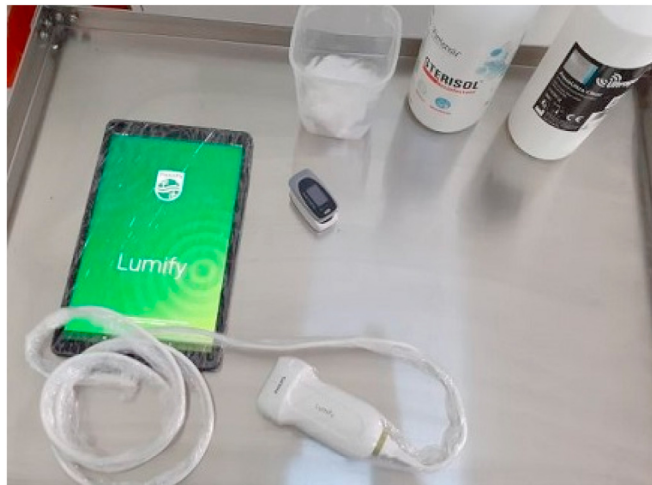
The portable Philips Lumify Ultrasound with linear transducer (covered with plastic foil, protecting the ultrasound machine when disinfected).
